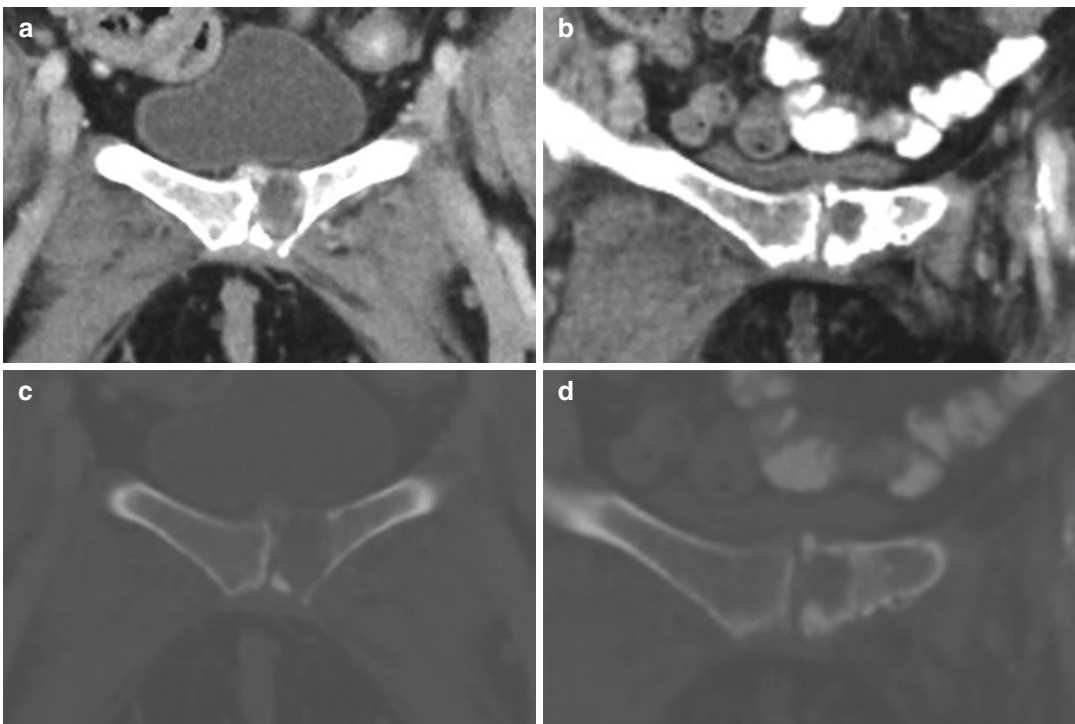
68-year-old woman with metastatic renal cell carcinoma treated with nivolumab and ipilimumab, and denosumab. Baseline CT in soft tissue (a) and bone (c) windows demonstrates a lytic lesion in the left pubic bone with peripheral rim soft tissue. Follow-up CT in soft tissue (b) and bone (d) windows demonstrates peripheral rim sclerosis of this lesion, representing partial response
